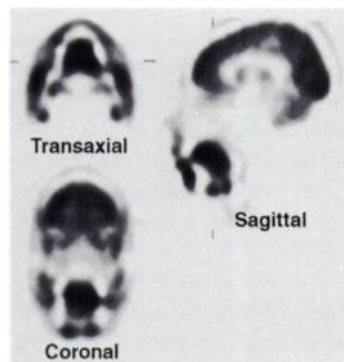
FDG-PET scan in a 38-yr-old man with a benign pulmonary nodule. There is high glucose uptake in the tongue, salivary glands and facial muscles due to chewing gum after the FDG injection.
